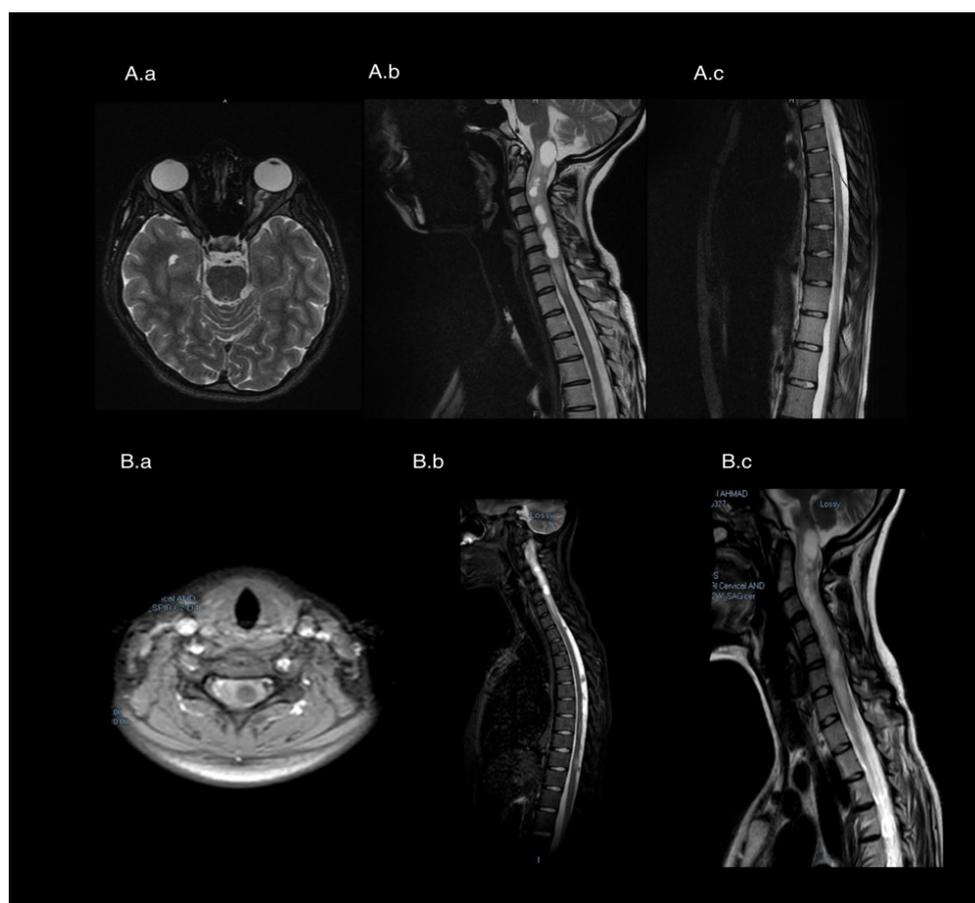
MRI of the brain and spine. (Aa): Brain MRI at presentation (T2-weighted axial sections); (Ab-Ac): Show sagittal T2-weighted MRI images of the cervical spine and thoracic spine, respectively; (Ba): Shows an axial T1-weighted MRI image of the spine; (Bb-Bc): Show sagittal T1-weighted MRI images of the spine.
